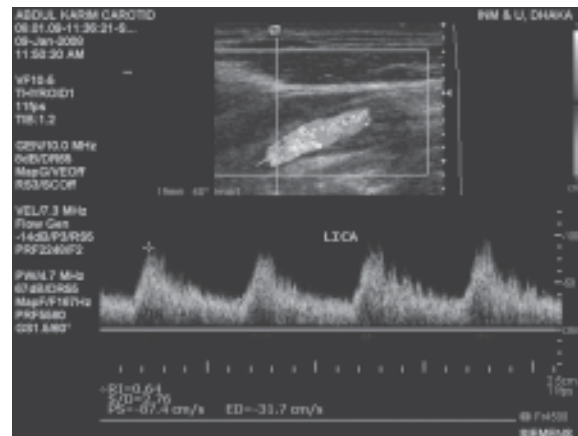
Doppler spectrum in LICA*
